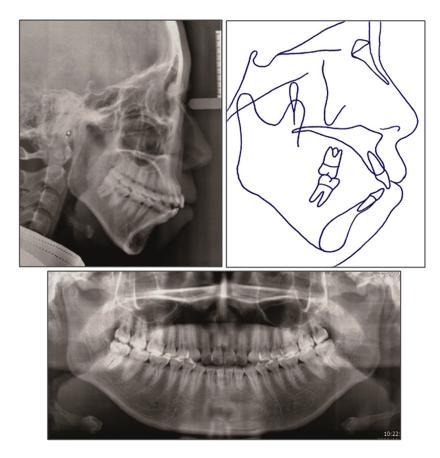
Pretreatment cephalograph, tracing, and panoramic radiograph.
